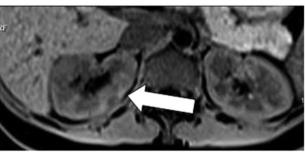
Fig Acute inflammatory changes in the right kidney on DMSA-SRS (A) and DW-MRI (B) in our study.
